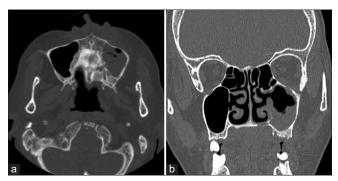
Plain CT (a) axial and (b) coronal image show erosion along the left side of the hard palate
